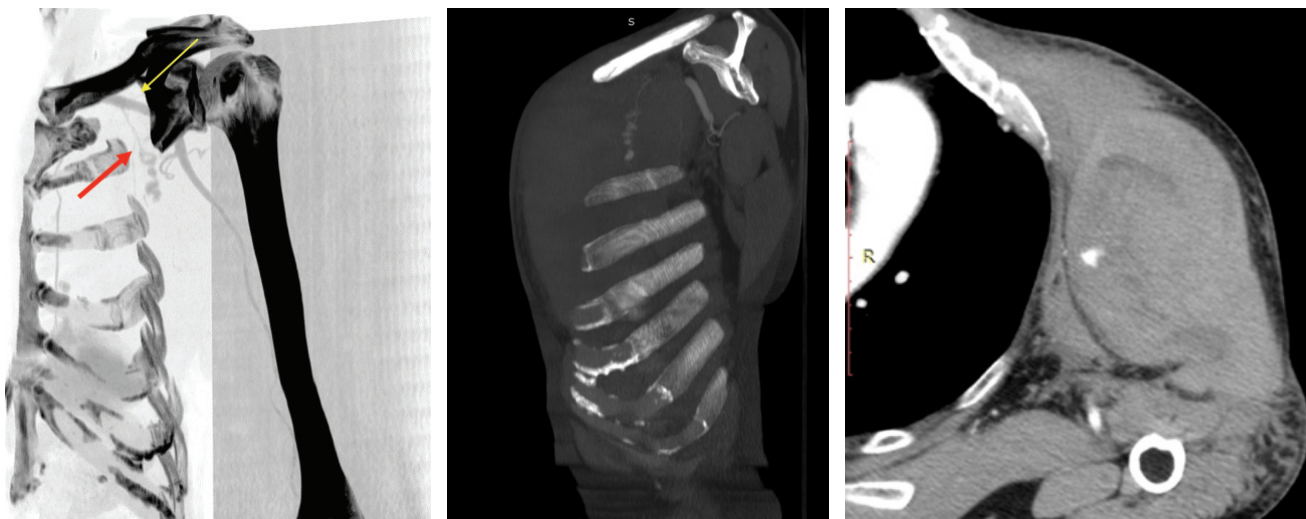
CT angiogram showing rupture of subclavian artery branch. 3A. Contrast leakage due to rupture of the branch (red arrow) originating from the subclavian artery (yellow arrow). 3B and 3C. Bleeding area of the left subclavian artery branch. Hypodense heterogeneous appearance with dimensions of 12x8 cm is observed at the widest point. There are necrotic areas in the center of the lesion in the left axillary area.
